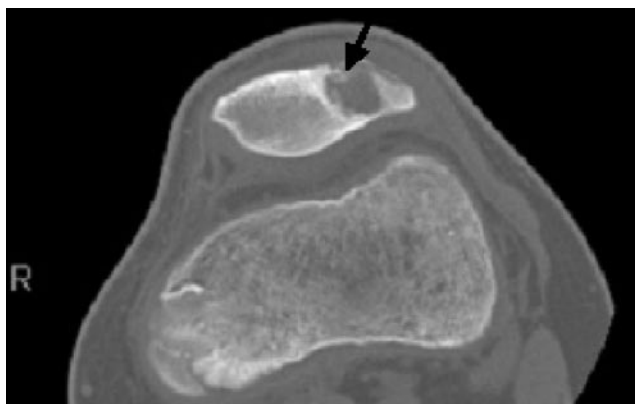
Computed tomography scans of the left knee: (A) axial and (B) sagittal.
